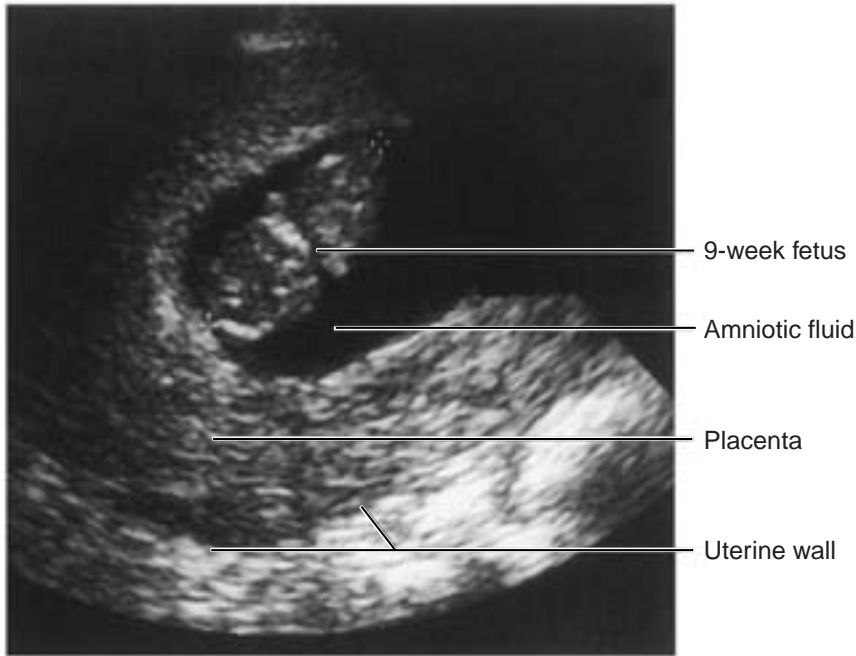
Sonogram showing a 9-week-old fetus. (Reprinted with permission from Erkonen WE. *Radiology 101: Basics and Fundamentals of Imaging*. Philadelphia: Lippincott Williams & Wilkins, 1998.)
